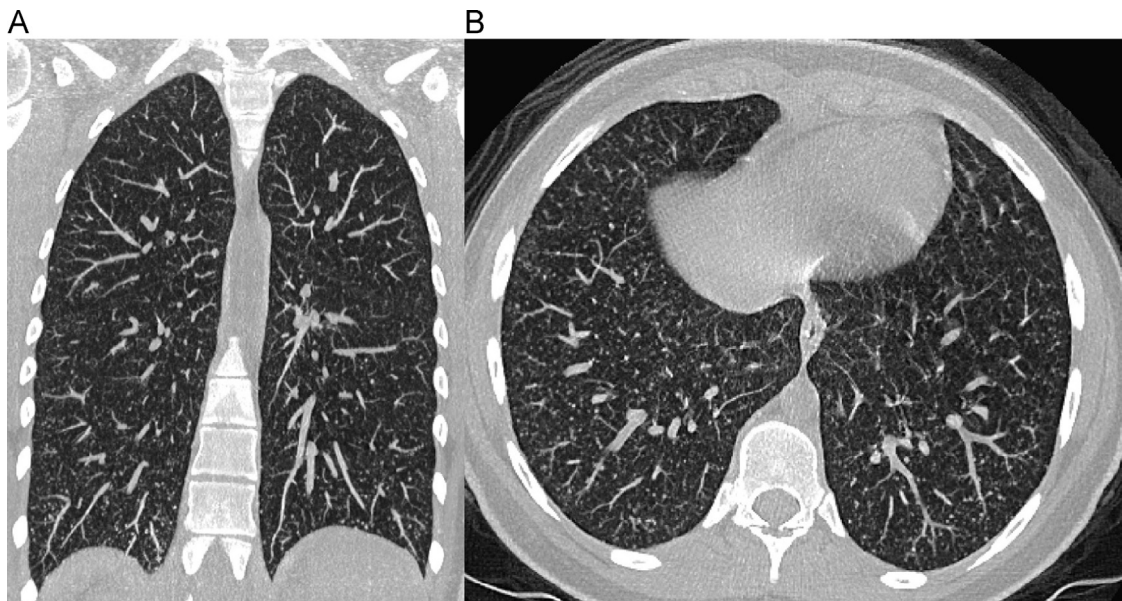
Papillary thyroid carcinoma metastatic to lungs. A 15-year-old girl with PTC, Stage II (T4a, N1b, M1); this is the same patient as in Fig. 2. A 5-mm coronal (A) and axial (B) maximum-intensity-projection image from a non-contrast-enhanced CT of the lung demonstrate numerous bilateral miliary lung nodules. Pulmonary metastases occur at presentation in as many as 20% of children with PTC.
